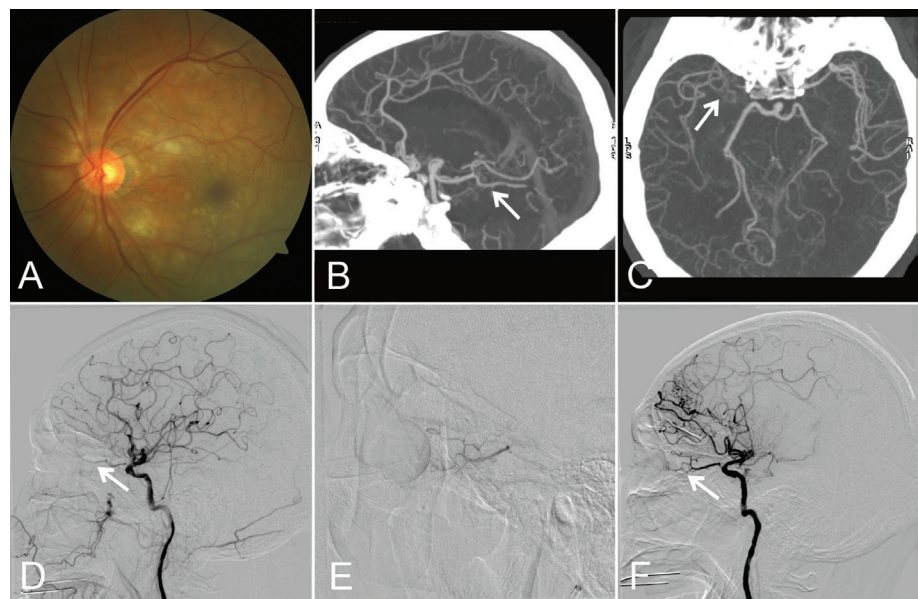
Case 1 imaging findings A: Left fundus image at disease onset; B–C: CTA image showing characteristic MMD vessels; D: Cerebral angiography before thrombolytic injection; E: Cerebral angiography during the thrombolytic injection; F: Cerebral angiography after the thrombolytic injection. CTA: Computed tomograph angiography; MMD: Moyamoya disease.
